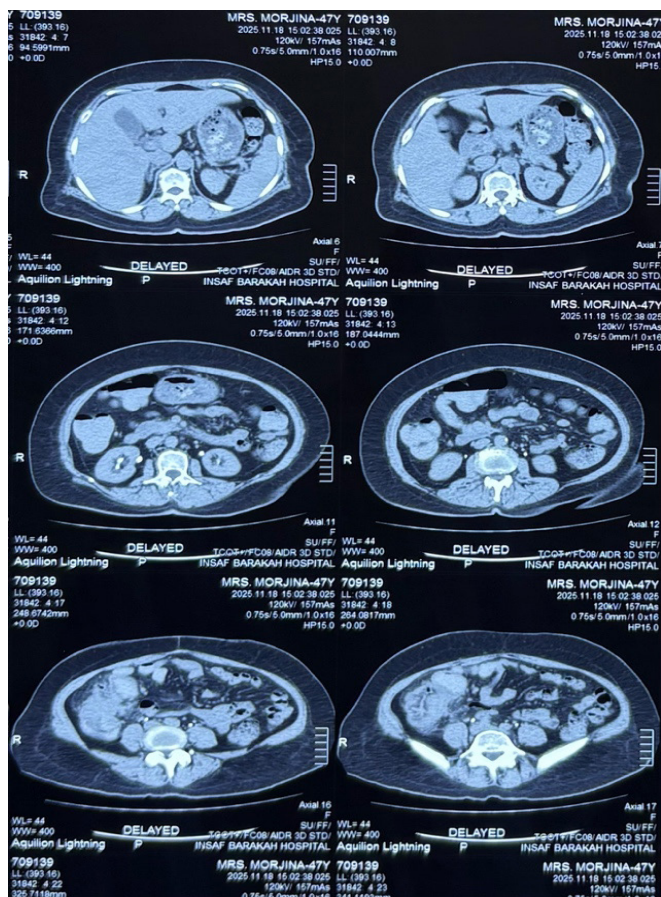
Contrast-enhanced CT: (A) Axial section showing heterogeneously enhancing caecal mass; (B) Coronal and sagittal reconstructions highlighting appendiceal inflammation and pericaecal fat stranding.
